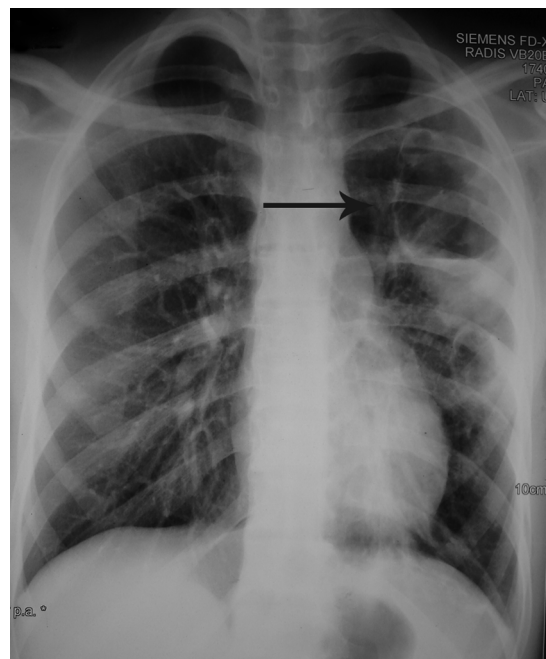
Chest radiograph shows a left-lung cavitory lesion with an air/fluid level (arrow).
